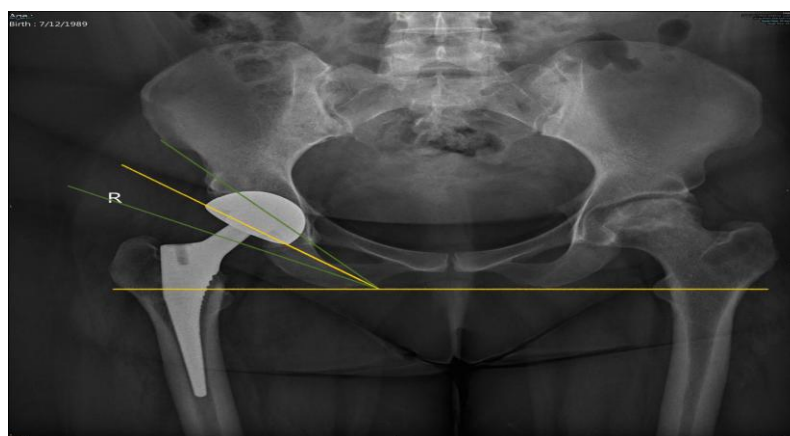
Post-op Xray of patient showing acetabular inclination (40 degrees) between the yellow lines with green lines depicting the safe zone for inclination (30-50 degrees).
